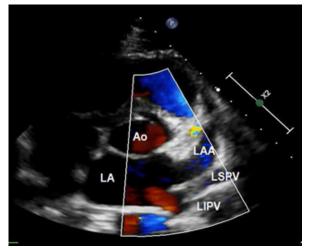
Parasternal short axis view. Color Doppler. On the lateral wall of the left atrium 3 structures can be seen: the most anterior is the left atrial appendage with a large ostium; in close proximity to the LAA drains LSPV which has an anterior to posterior direction; LIPV drains in the posterior region of LAA having a posterior to anterior direction.
